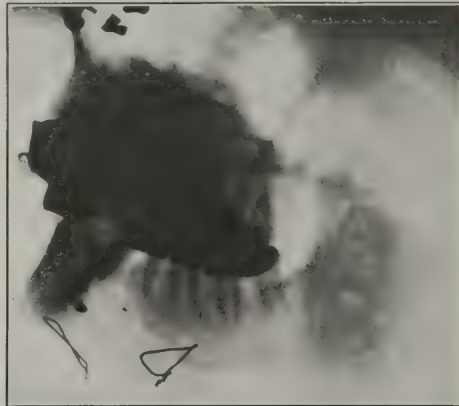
Case 9: Radiograph taken one month after operation, showing bone graft in place.
